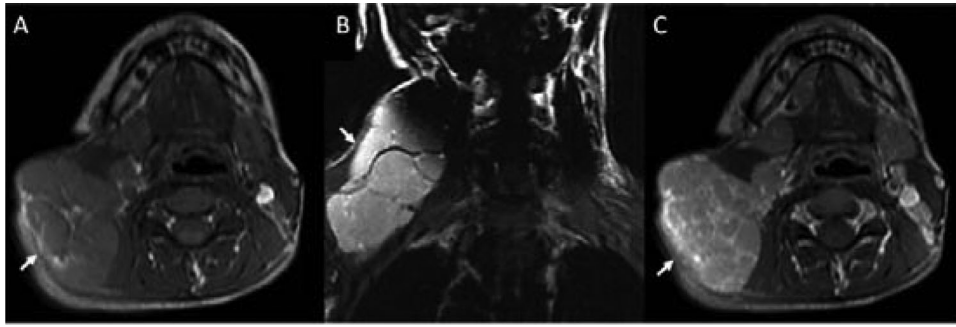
Axial T1-weighted (A), coronal fat-suppressed T2-weighted (B), and axial contrast-enhanced fat-suppressed T1-weighted (C) MR images of a child with a lymphoma. The images show a large mass in the right posterior cervical triangle. Multiple contiguous enlarged lymph nodes are demonstrated and show trans-spatial extension (A, C) and caudal extension of involved lymph nodes in continuum (B). The postcontrast images (C) reveal peripheral enhancement of the enlarged lymph nodes with central focal areas of absent enhancement (necrosis).
